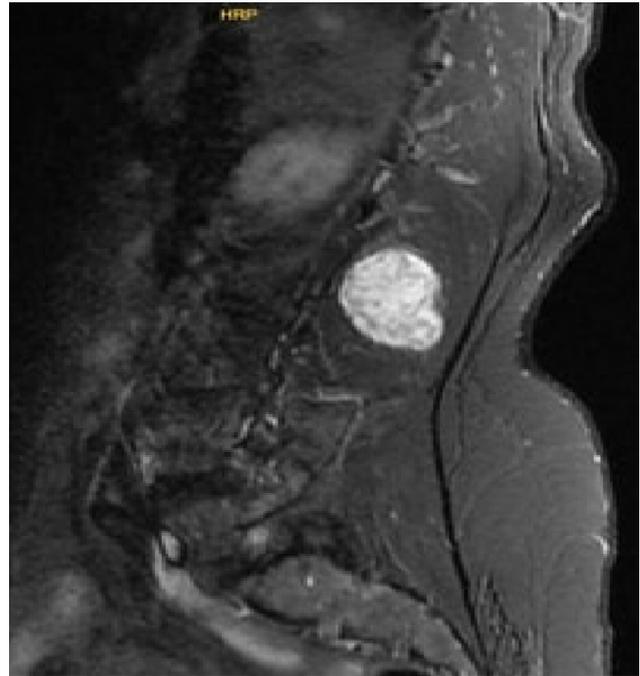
Contrast lumbar MRI was performed on the same patient. It showed well-circumscribed spherical tumor with homogeneous contrast enhancement.
